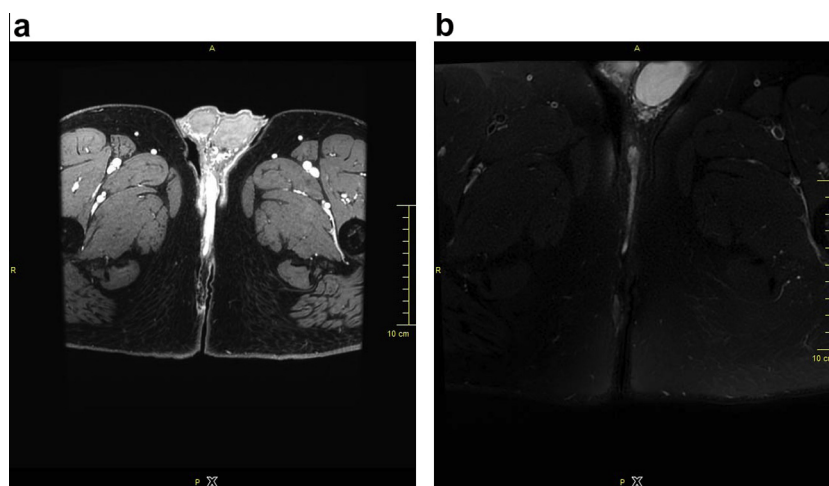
(a–b): Axial T2-weighted (a) and post contrast LAVA (b) images displaying sinus tract coursing anteriorly along the medial aspect of thigh reaching perineum and scrotal junction.
